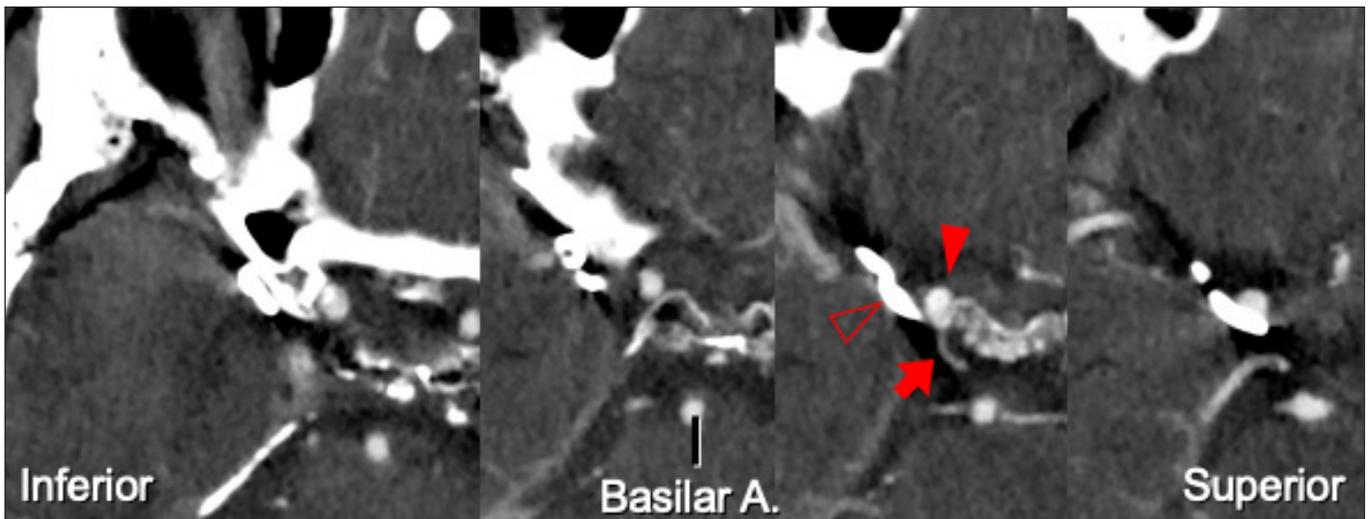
Postoperative serial computed tomography (CT) angiographical images. Complete obliteration of the posterior communicating artery (PComA) aneurysm while preserving the PComA is confirmed (red arrow: PComA, open red arrowhead: clip, close red arrowhead: internal carotid artery). A: Artery.
